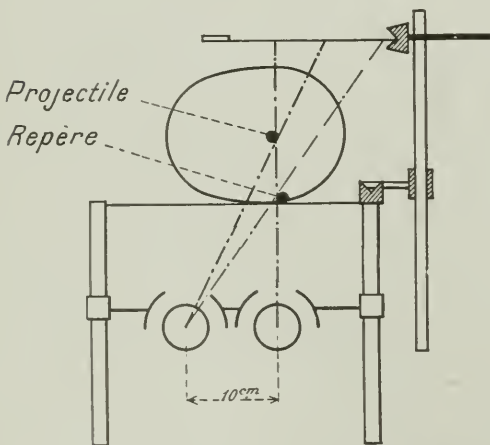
LOCALIZATION OF A PROJECTILE BY A MARKER ON THE POSTERIOR ASPECT. THE INDICATOR IS PLACED ON THE OPPOSITE SIDE OF THE EXCURSION OF THE TUBE.
